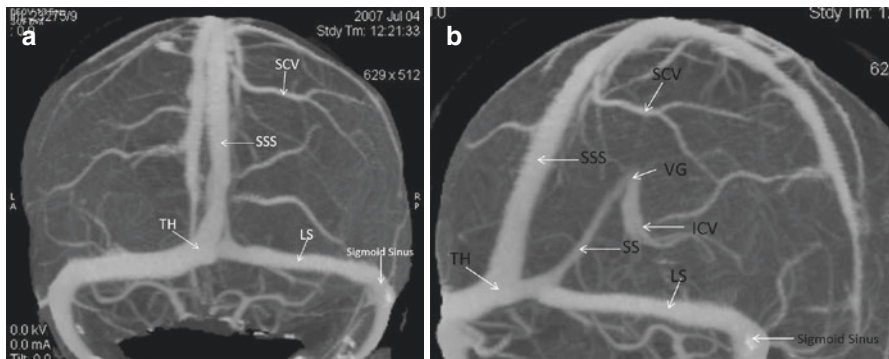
(a) CT Venography of the brain (MIP reconstructions-AP View). *White arrows* indicate main venous sinuses and veins. SSS superior sagittal sinus, SCV superior cerebral vein, LS lateral sinus, TH torcular herophili, (b) CT Venography of the brain (MIP reconstructions-Oblique View). *White arrows* indicate main venous sinuses and veins. SSS superior sagittal sinus, SS straight sinus, SCV superior cerebral vein, LS lateral sinus, TH torcular herophili, VG vein of Galen
